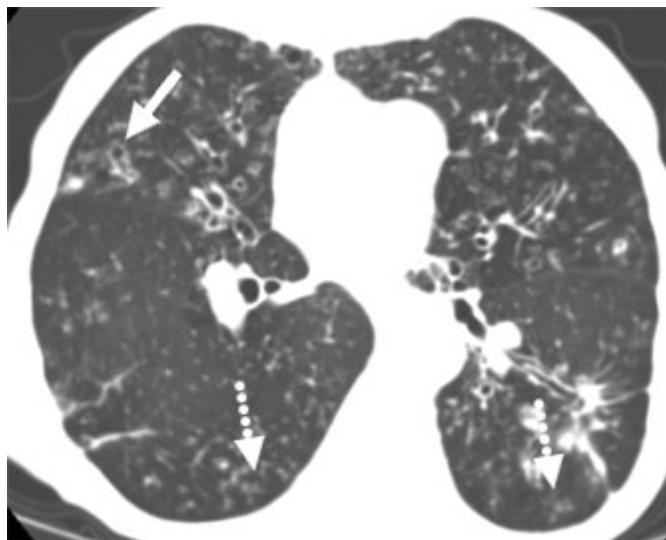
83 year old lady with a chronic cough. CT scan at the level of the pulmonary artery demonstrates bronchiectasis (solid arrow) and tree-in-bud nodules (dashed arrows) involving the middle lobe, lingula and lower lobes, secondary to MAC
